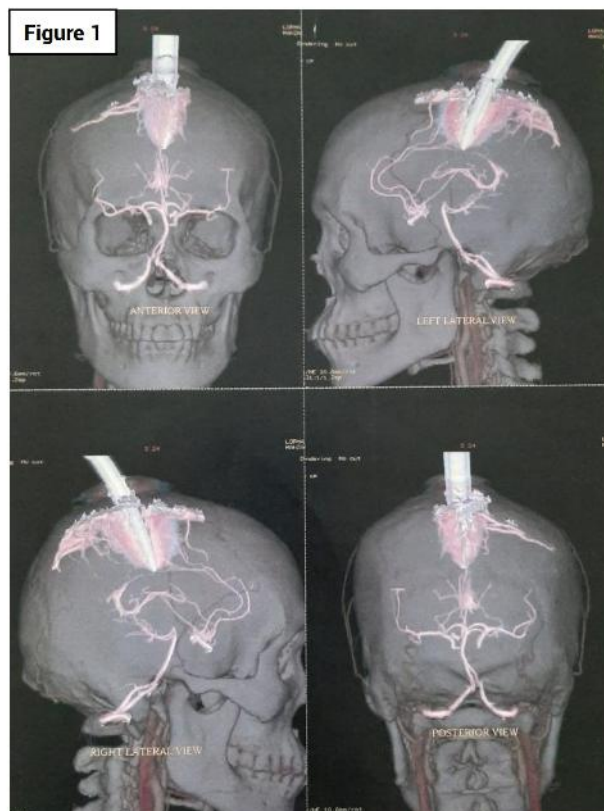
CT angiogram of the head showed penetrating brain injury with a sharp metallic object crossing the skull bone with entry point in the parietal bone along the midline through the sagittal suture. The tip is situated just before the body of the corpus callosum. The adjacent brain parenchyma cannot be adequately assessed due to streak artifacts. The penetrating object appears to pass through the mid-sagittal sinus. Dilated cortical veins noted predominantly in the frontal region. Unremarkable circle of Willis.
